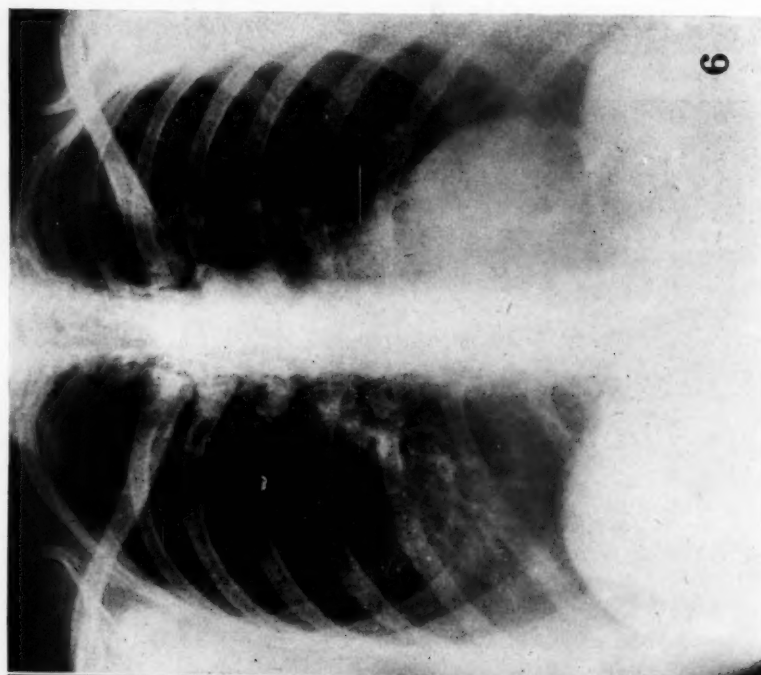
Radiograph of the chest taken on June 24, 1947, showing no pulmonary or cardiac abnormality.
